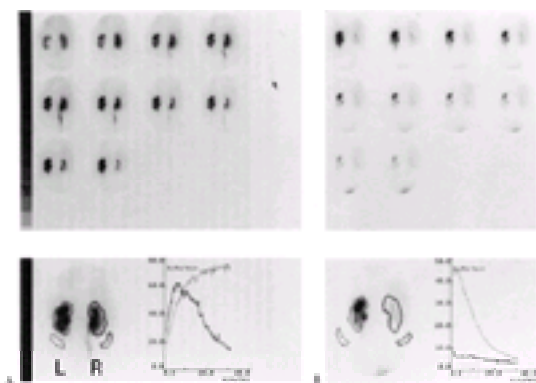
Furosemide renal scan. Patient with known hydronephrosis by ultrasound presented for evaluation of possible obstruction. A: Thirty-minute ^{99m}Tc -MAG3 functional images and renogram demonstrate steadily increasing counts in the left kidney (lighter gray curve). B: Images obtained immediately following injection of intravenous furosemide. Counts in the left kidney rapidly decrease, confirming a nonobstructed excretory system.
